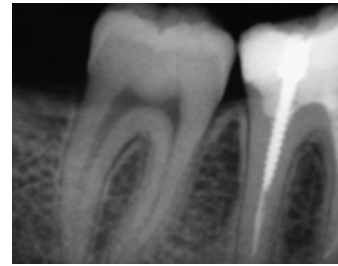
Periapical radiograph at 6 months confirms an adequate bone regeneration.
